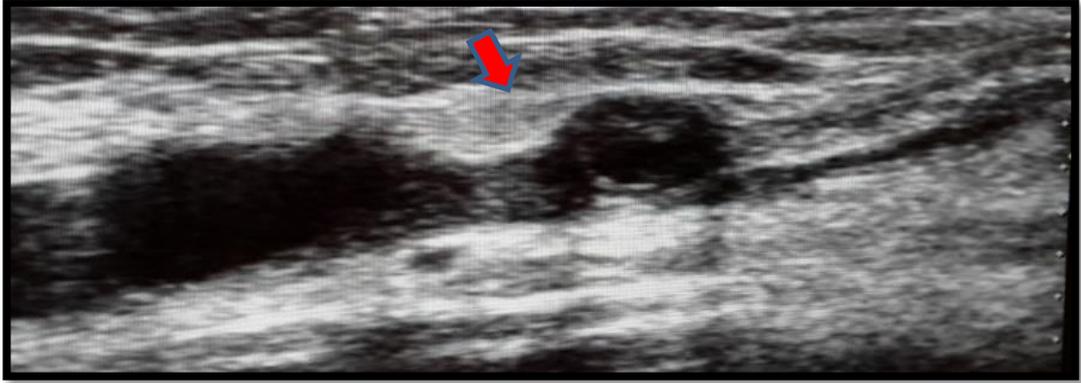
Preliminary ultrasound shows juxta-anastomosis site of stenosis (red arrow).
